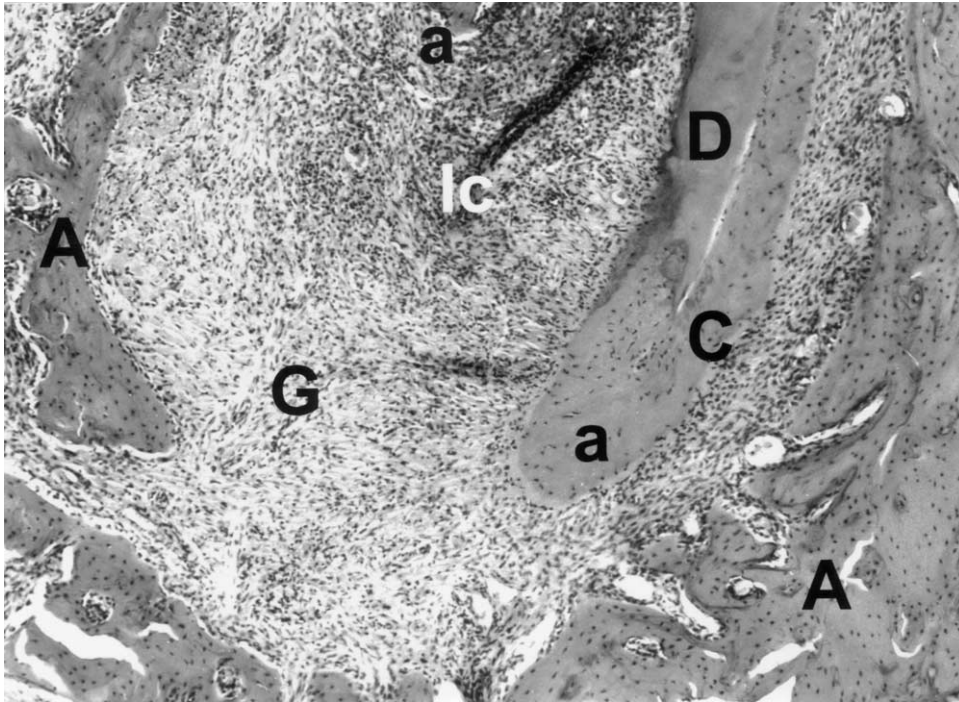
Two weeks after placement of CP-1 in the apical root canal. Inflammatory reaction was observed in the periapical area near the apical foramen. Polymorpho-nuclear leucocytes were present. lc: Inflammatory cells; G: Granulation tissue; D: Dentin; a: Apex; A: Alveolar bone; C: Cementum (Orig. Mag.  $\times 16.0$ ).
